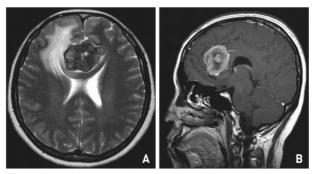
Magnetic resonance image showing a lobulating mass attached to the falx. Mass with severe peritumoral edema compressing anterior cerebral arteries (ACA) on T2 weighted axial view (A). T1 enhanced sagittal view showing encasement of the ACA by the tumor (B).
